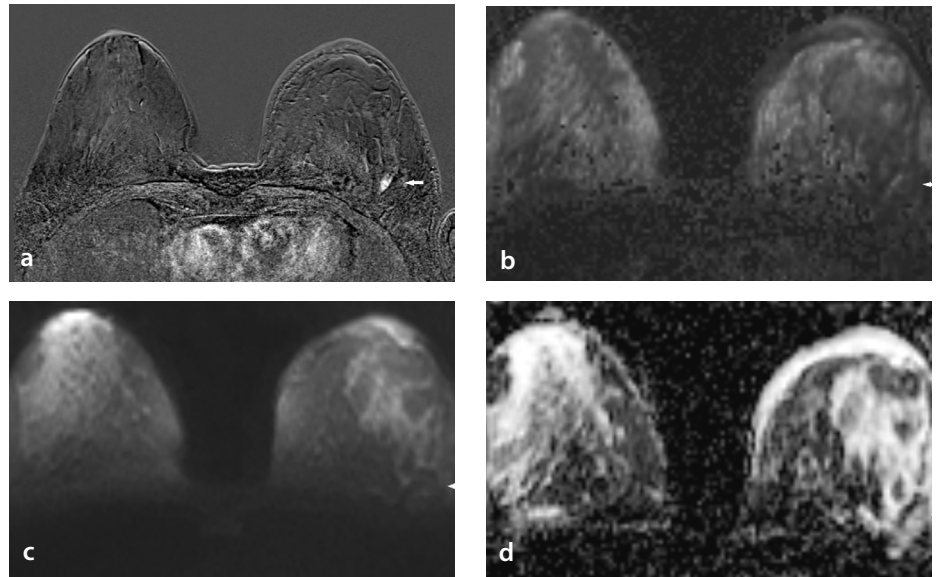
A 64-year-old female patient with a diagnosis of Luminal B IDC in the axillary tail of the left breast is observed. In the dynamic contrast-enhanced image (a), there is an enhanced non-mass lesion, which is a potential malignancy. Synthetic diffusion-weighted image (b) showed lesion isointense. Conventional diffusion-weighted image (c) showed lesion isointense and DWI was evaluated with ADC map (d) there is diffusion restriction in the lesion. The average ADC value was $1.003 \times 10^{-3} \text{ mm}^2/\text{sec}$, which is below the cut-off value ($1.189 \times 10^{-3} \text{ mm}^2/\text{sec}$). IDC, invasive ductal carcinoma; DWI, diffusion-weighted imaging; ADC, apparent diffusion coefficient.
